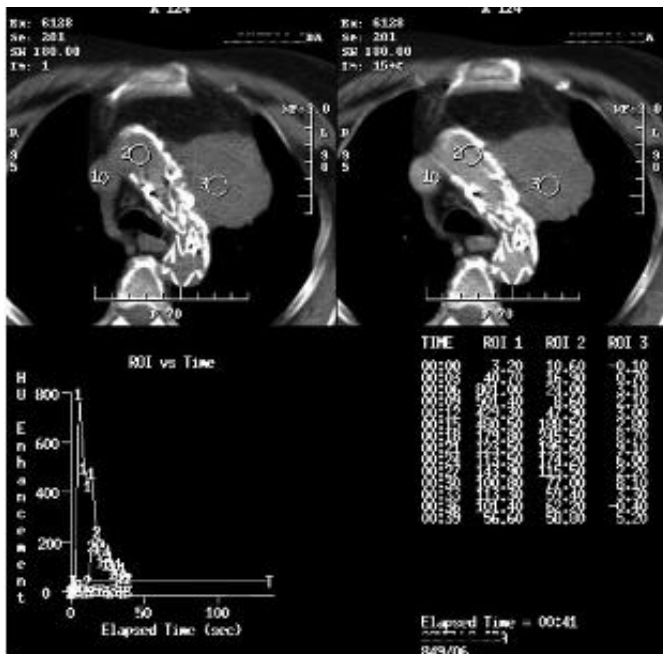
Axial CT image Contrast material-enhanced follow-up at twenty days after the procedure, suggested progressive thrombosis of the pseudoaneurysm sac.
